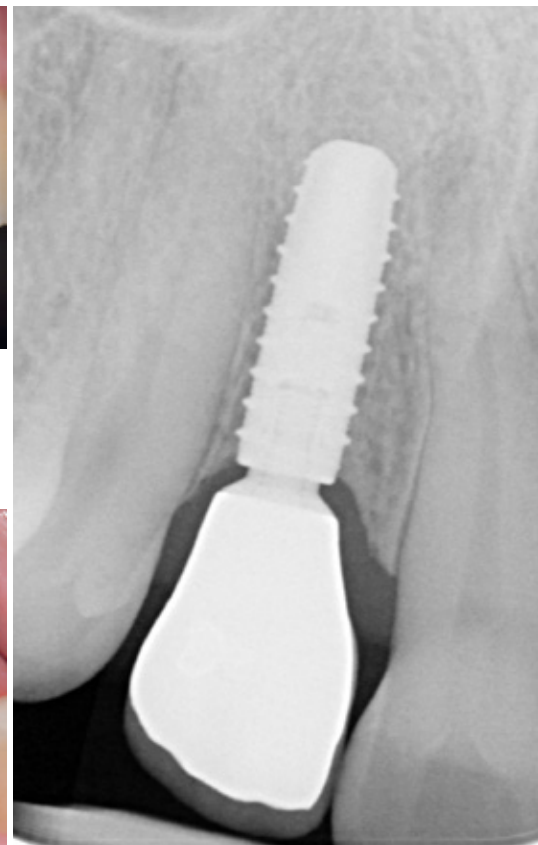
The control radiograph reveals the outstanding osseointegration with the platform switching achieved with the system.
